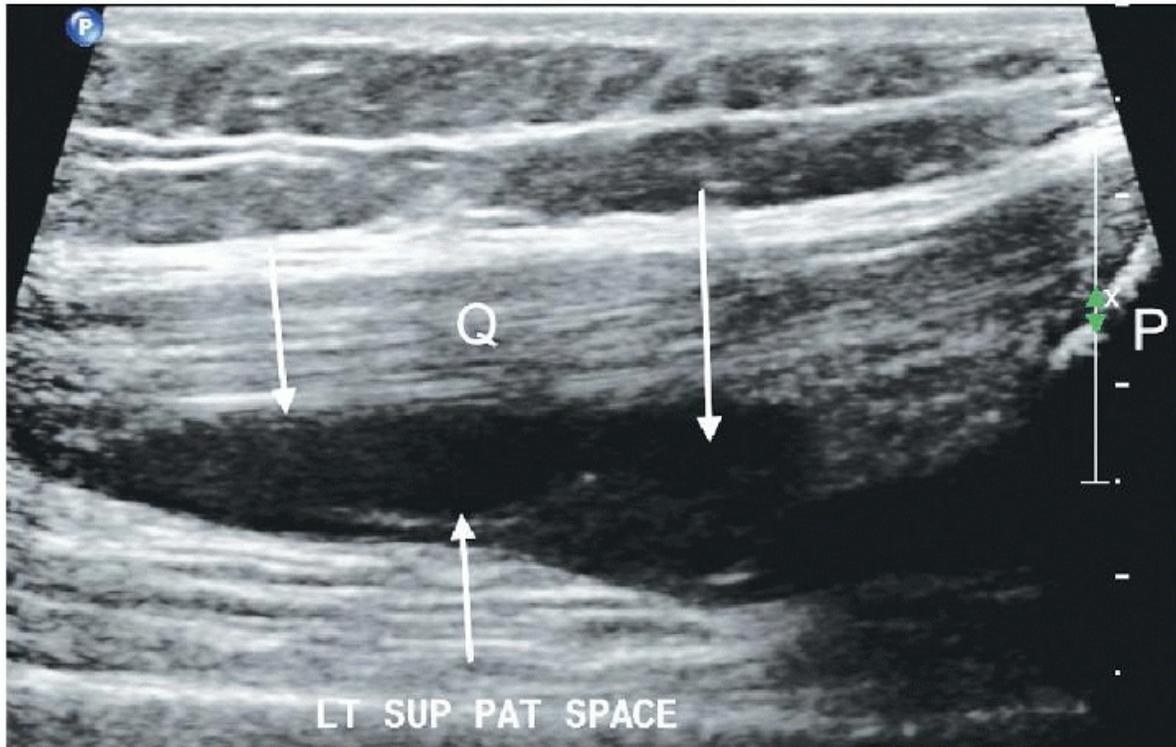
Longitudinal ultrasound image demonstrating fluid in the suprapatellar recess (arrows). Q, quadriceps tendon; P, patella. P. 140
